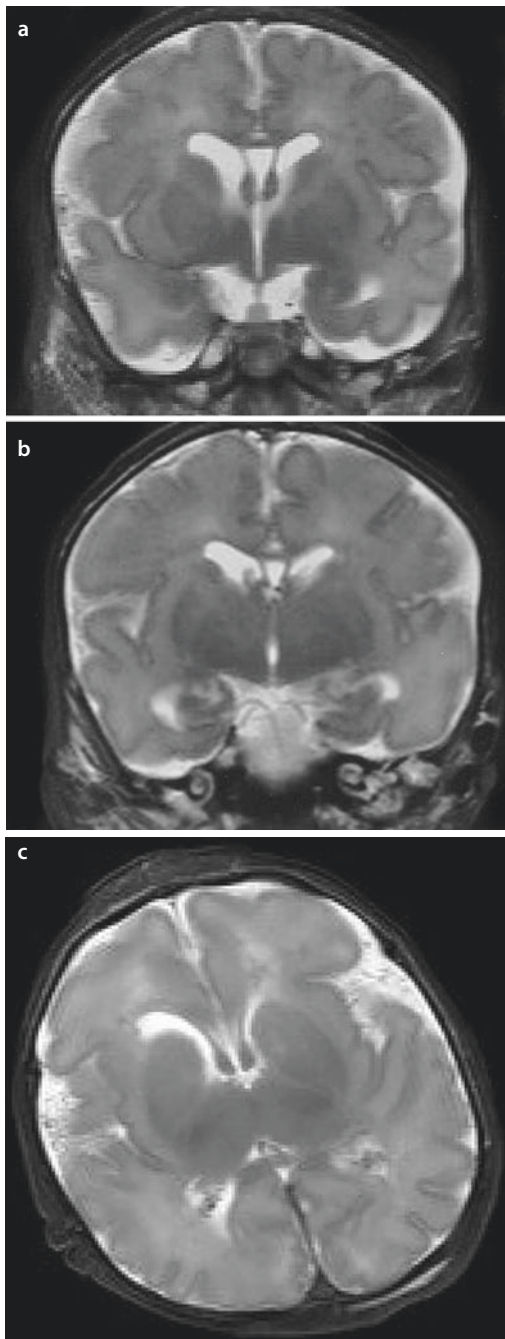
Foetal T2-weighted MRI taken at the 35th week of development. Two frontal (or coronal: a, b) and one axial c sections show increasing development of the insulae and lateral fissures, and an increasing number of gyri and sulci. The basal ganglia (in a), the amygdala (in a) and the hippocampal region (in b) are easily recognized. Note the large cavum septi pellucidi and the prominent fornices (in a and b). The corpus callosum is visible in a and b, whereas in c the development of the insula can be observed. (Courtesy of Ton van der Vliet, Groningen)
